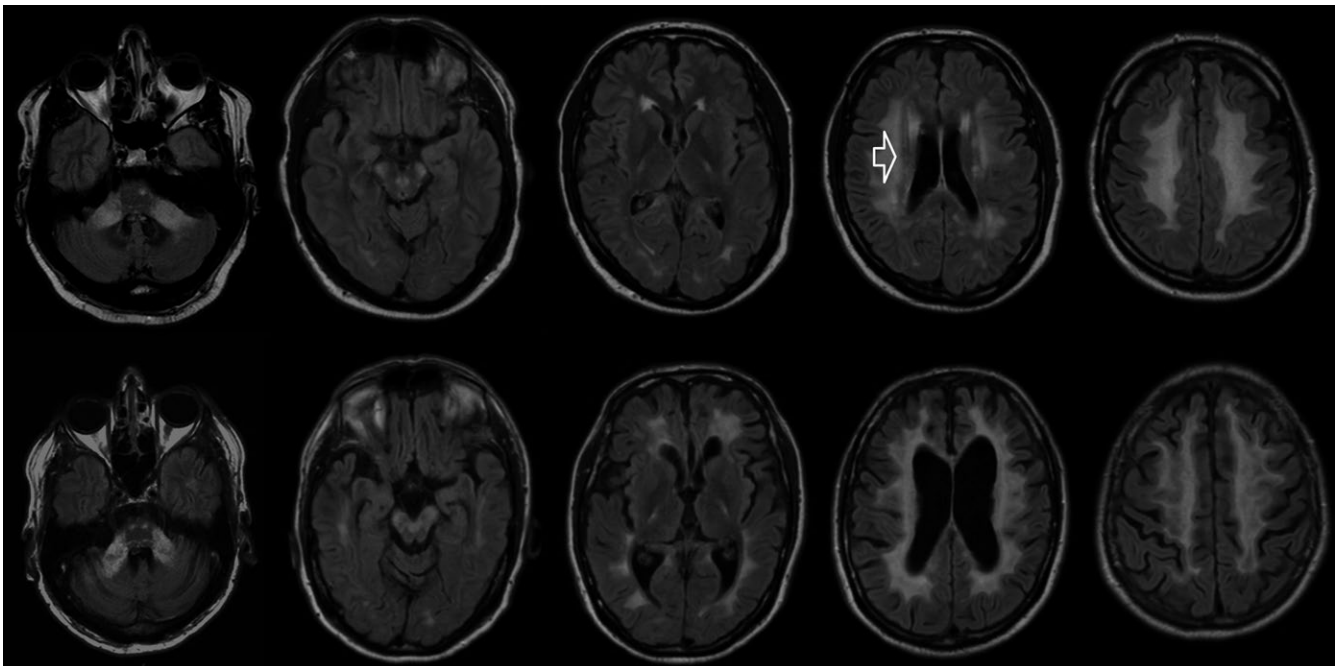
MR images of the least and most severely affected patients. Patient 8, top row, presenting MRI grade 3 changes with T2 hyperintensities in the cerebellar peduncles, along the corticospinal tracts and in the supratentorial white matter in the frontal, parietal, and occipital lobes. A less affected periventricular rim can be seen (arrow). Patient 5, bottom row, presenting grade 5 changes with extension of the white matter changes into the temporal lobes as well as enlargement of ventricles and sulci. T2-weighted fluid attenuation inversion recovery (FLAIR) sequence
